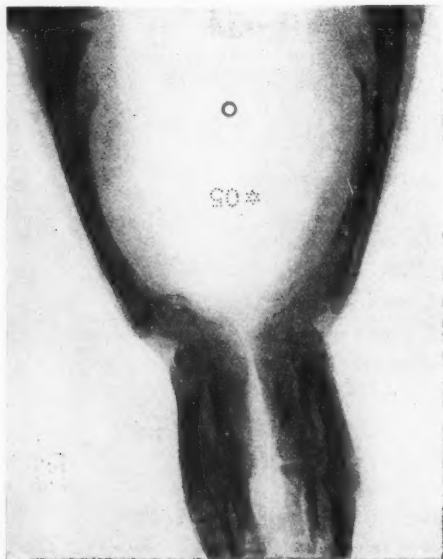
Radiograph of forearms, wrists, and hands.
